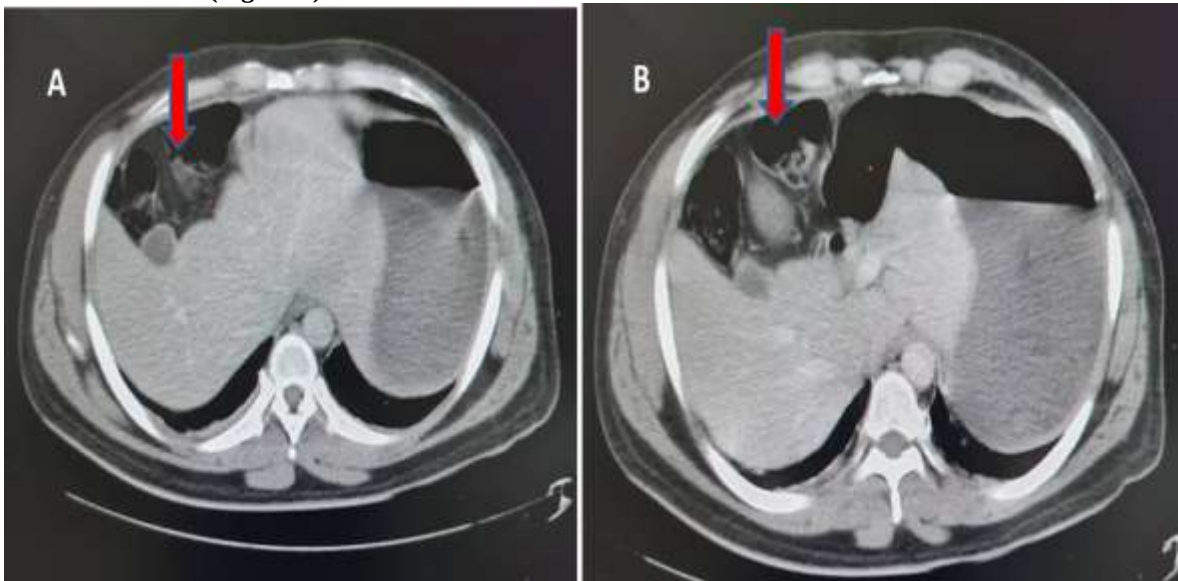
(A and B) CT in axial reconstruction after injection of contrast medium showing the interposition of the loops in the right inter-hepato-diaphragmatic area.
